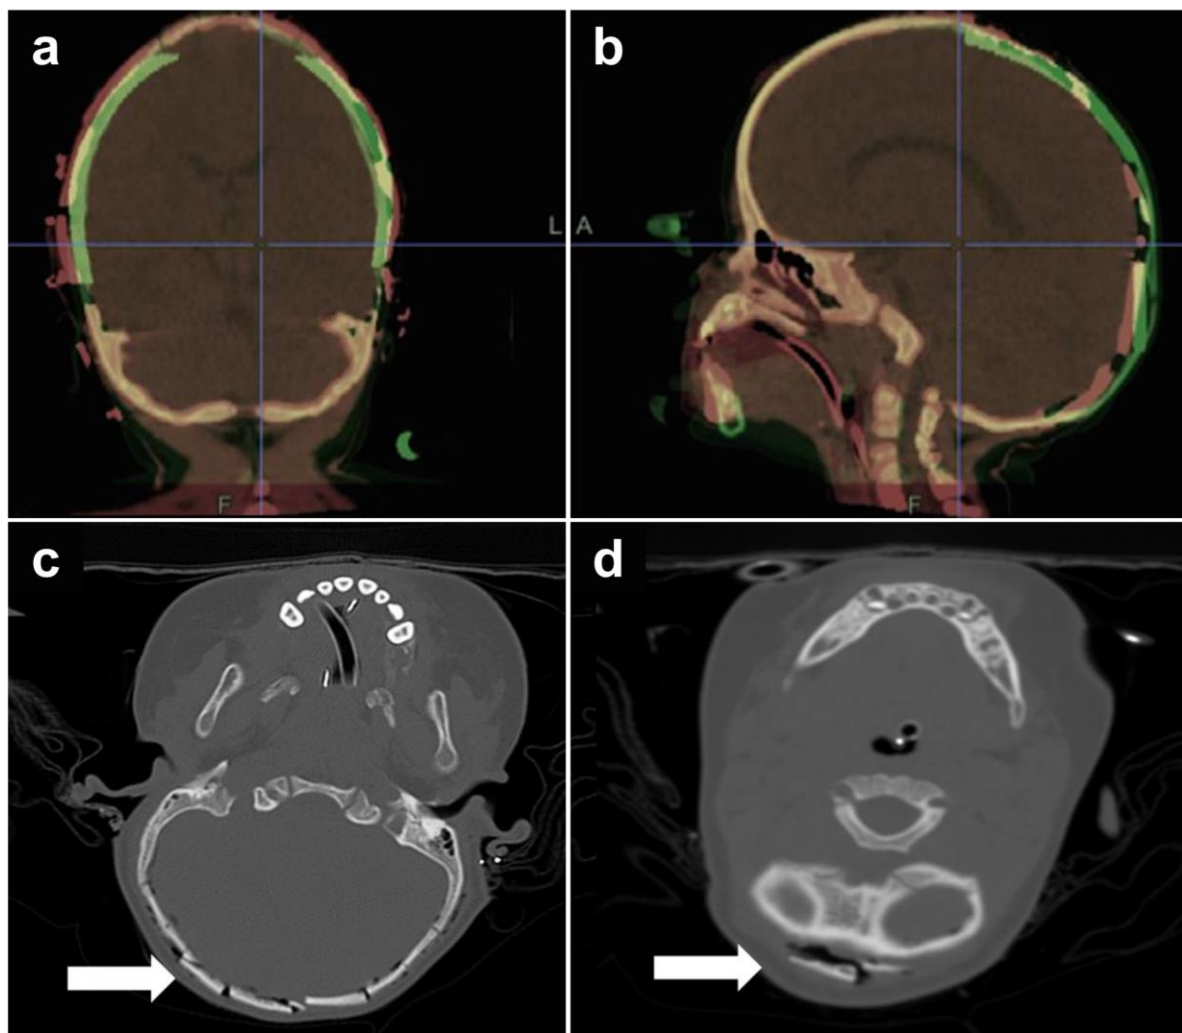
Intraoperative CT scan acquired during surgical correction of a patient with sagittal craniosynostosis. VSP is overlaid in green in the coronal (a) and sagittal (b) slices of the CT scan for comparison. Axial slices show misplaced bone fragments in the suboccipital region (c and d). Image adapted from [55] (figure reprinted with permission from the copyright holder, Springer Nature).
